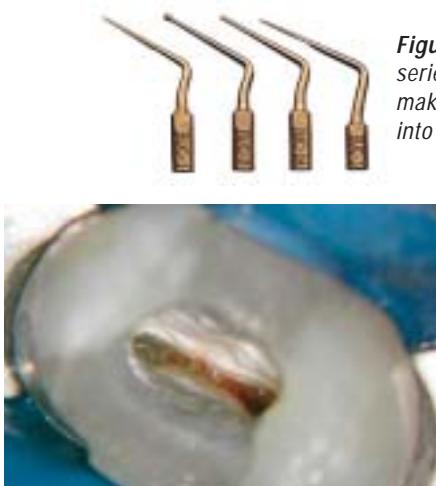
Ultrasonic tips such as this series from SybronEndo (800) 346-3636, make locating and initial penetration into root canals fast and efficient.
